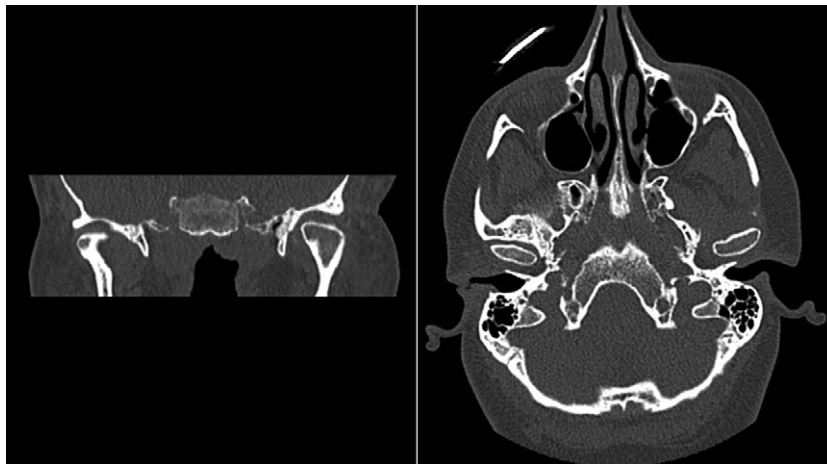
Initial CT (coronal and axial sections): expansion of the left TMJ articular space.
